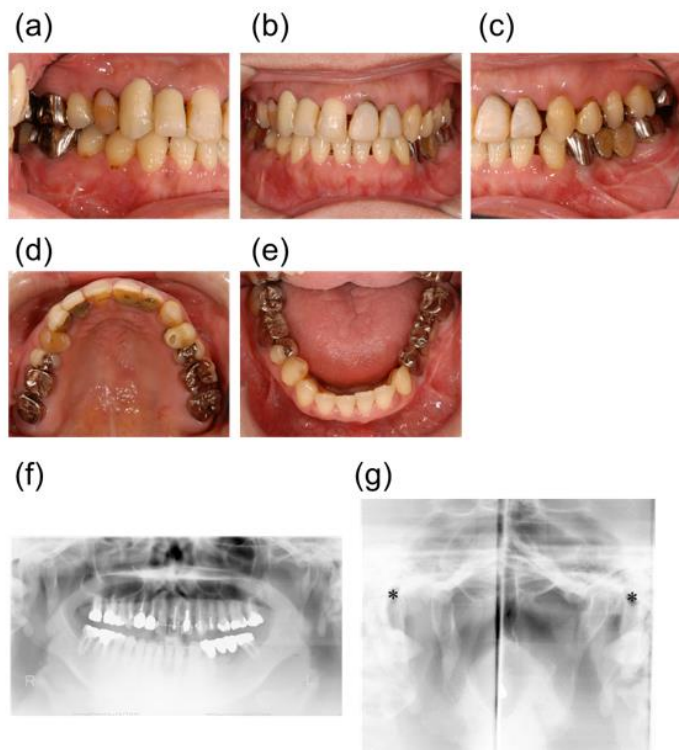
Postoperative intraoral photographs and radiographs at the revisit. A) Right molar relationship, B) frontal view, and C) left molar relationship in centric occlusion. D) Upper and E) lower occlusal view (flipped mirror image). F) Panoramic radiograph. G) TMJ radiographs at closed mouth position. Asterisks: The external auditory foramina.
